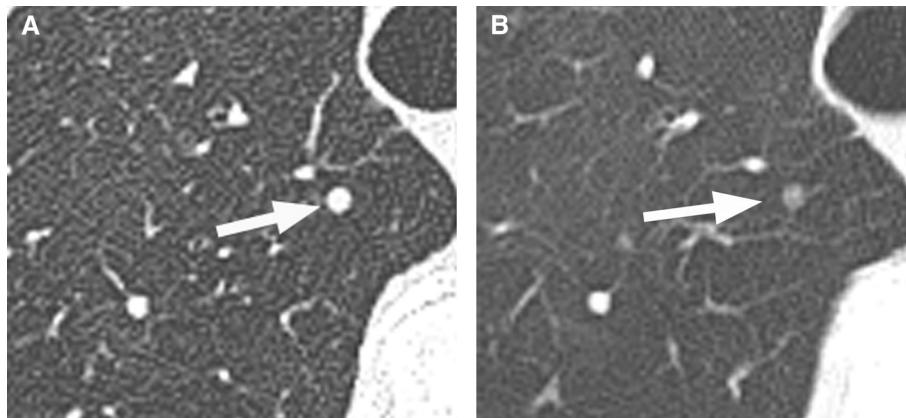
Effect of volume averaging on perceived nodule density. (A) Unenhanced computed tomography, with 1-mm slice thickness reconstructed axial images, demonstrating a 4-mm solid nodule (arrow). (B) When the same source data are reconstructed at 5-mm slice thickness, the nodule appears as ground glass (arrow).
